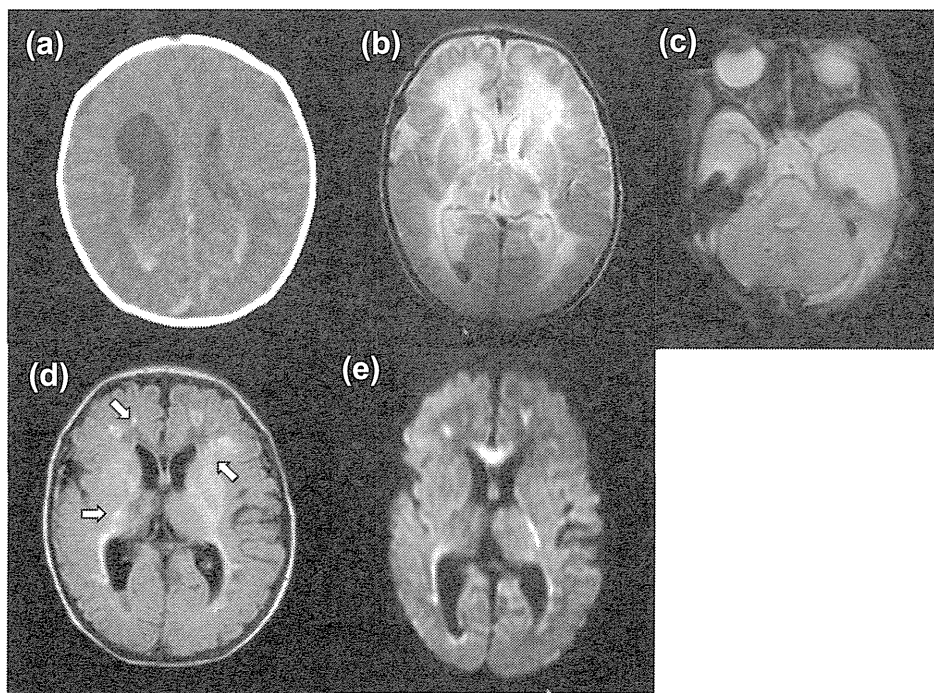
Computed tomography (CT) of the brain on admission (a) indicates obsolete hemorrhagic lesions in bilateral ventricles and subarachnoid cavities and low intensity area in the right frontal lobe. Magnetic resonance imaging (MRI) of the brain on day 8 after birth (b–e) indicates multiple infarctions including obsolete (d, arrows) and acute lesions, along with bilateral ventriculomegaly. T2-weighted image (b) shows multiple low intensity areas in the left frontal lobe, the left frontal horn of lateral ventricle and bilateral cerebellar hemisphere. T2 star-weighted image (c) shows low intensity area in cerebellar hemisphere. Fluid attenuation inversion recovery (d) and diffusion weighted images (e) show multiple high intensity areas in different distribution.
